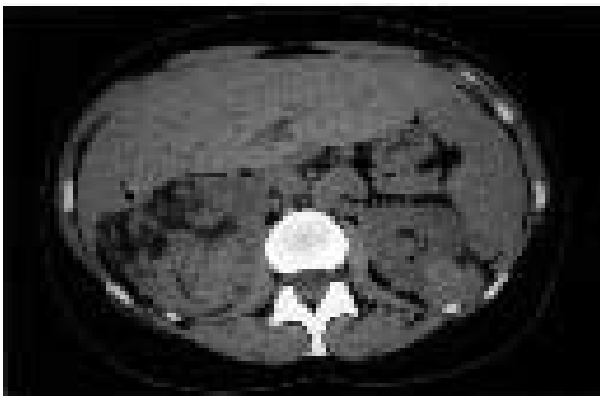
Axial unenhanced computed tomography (CT) of the kidneys of a 40 year old woman with lymphangioleiomyomatosis (LAM) showing typical bilateral angiomyolipomas with fat components (arrows).
